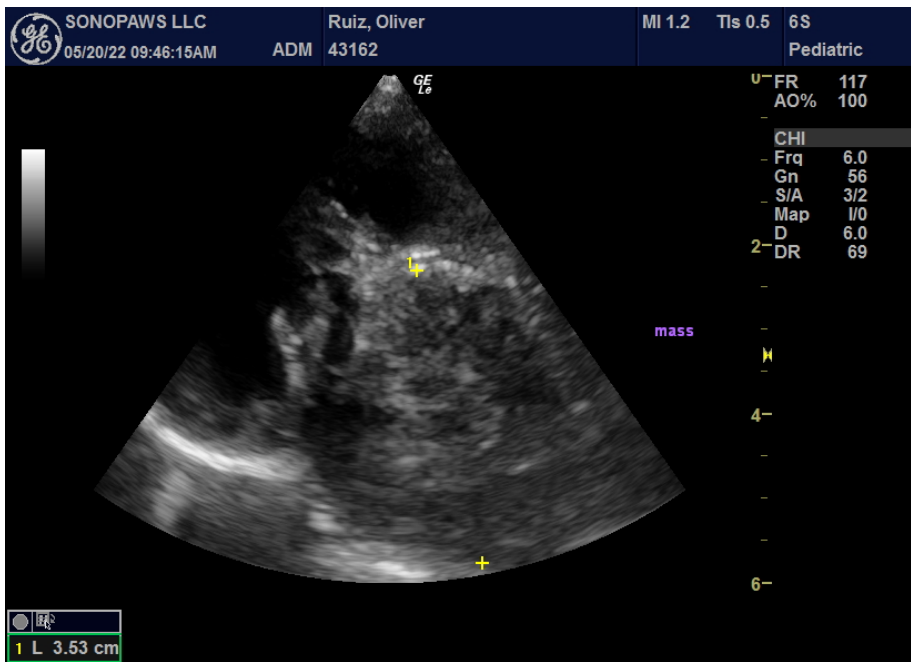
Right parasternal transverse view showing a 3.5cm hypoechoic heterogeneous mass.
